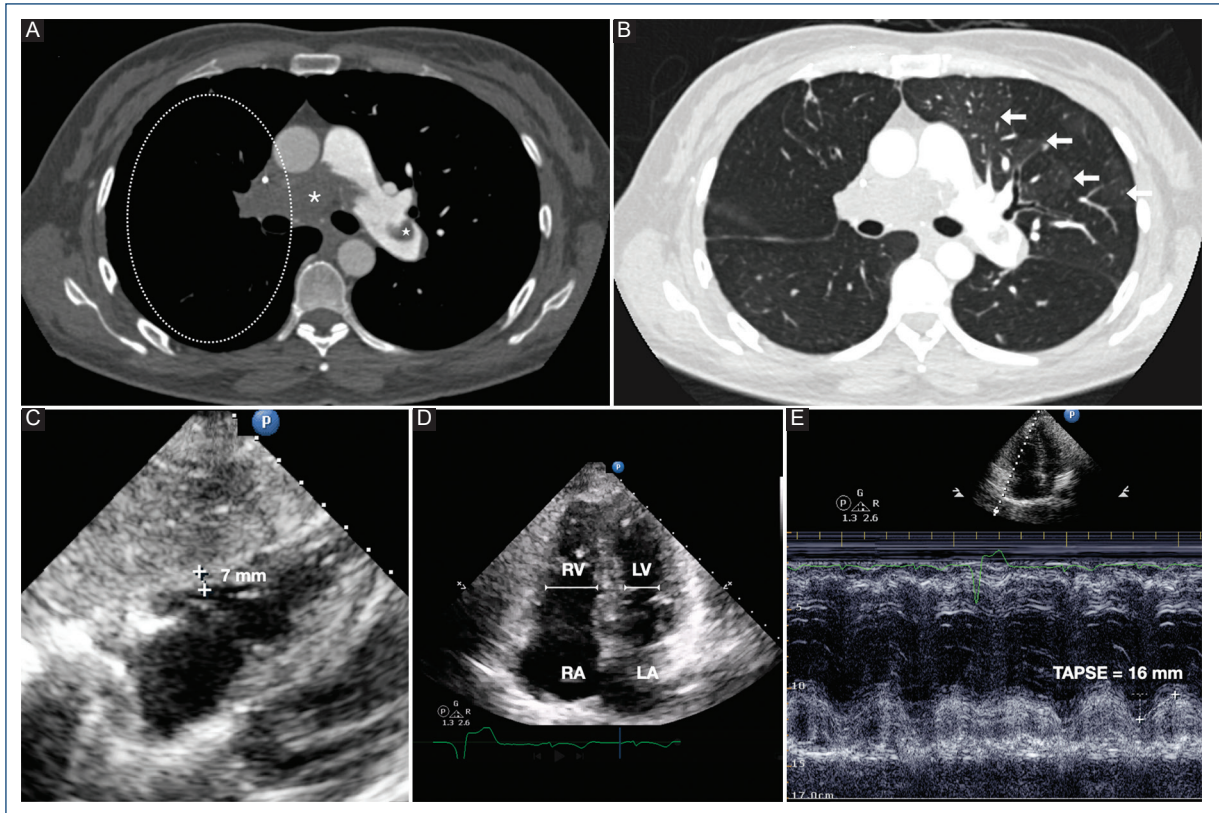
Computed tomography angiogram and transthoracic echocardiogram. A: axial section at the level of the pulmonary artery bifurcation in vascular window, demonstrates a thrombus completely occluding the lumen of the right pulmonary artery (asterisk), extending into the lobar and segmental branches. There is no opacification of the arterial branches within the ipsilateral lung (circle). Additionally, a partial thrombus is observed within the lumen of the left pulmonary artery (star). B: axial section at the level of the pulmonary artery bifurcation in lung parenchymal window, reveals a mosaic perfusion pattern on the left side (arrows), a finding suggestive of acute-on-chronic thromboembolism. The echocardiogram demonstrated evidence of right ventricular (RV) systolic dysfunction, a reduced fractional area change (FAC% = 27.7%), as well as dilatation and hypertrophy of the RV. C: subcostal four-chamber view, showing hypertrophy of the RV free wall measuring 7 mm. D: apical four-chamber view demonstrating, an RV/LV ratio of 1.43. E: M-mode in apical four-chamber view demonstrating, TAPSE of 16 mm. TAPSE: tricuspid annular plane systolic excursion; RV: right ventricle; LV: left ventricle; RA: right atrium; LA: left atrium.
